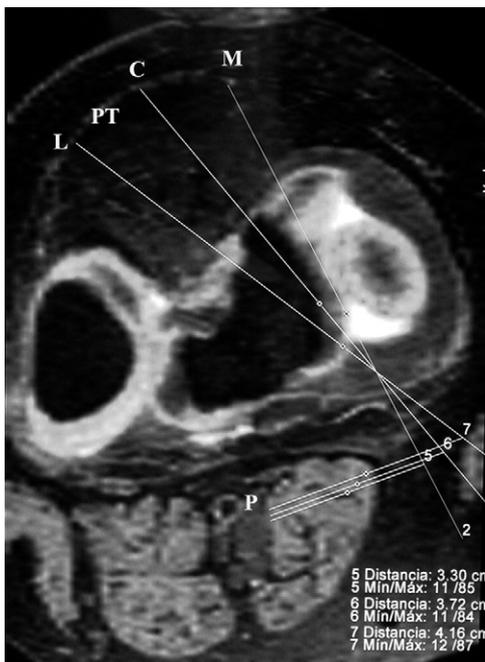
MRI cross section taken from a T2 me2D axial sequence showing the whole of the internal meniscus in a single shot. The lines drawn from points M (located medially to the patellar tendon), C (located at the center of the patellar tendon), and L (located laterally to the patellar tendon) converge upon a point on the posterior horn of the internal meniscus situated 10 mm from the root. P marks the popliteal neurovascular bundle.
